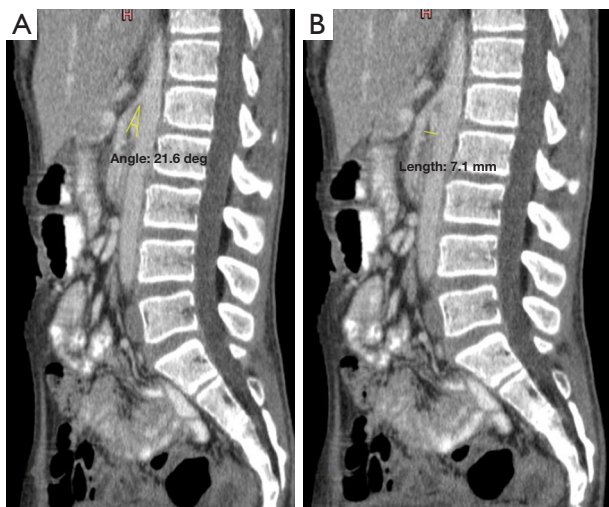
Repeated contrast-enhanced computed tomography scan of the abdomen 80 days post-discharge showing a slight improvement in the degree of compression, with (A) aortomesenteric increasing to 21.6° and (B) aortomesenteric distance of 7.1 mm, suggesting a slight improvement in the degree of compression.
